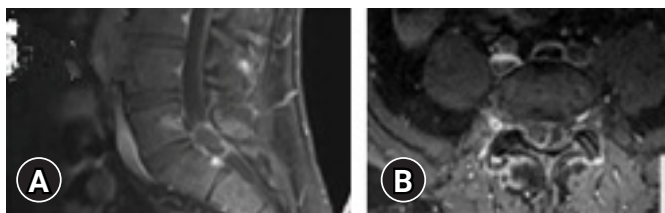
(A) Preoperative sagittal T1-weighted magnetic resonance imaging (MRI) with gadolinium enhancement displaying the L5-S1 intradural neoplasm. (B) Preoperative axial T1-weighted MRI with gadolinium enhancement displaying the L5-S1 intradural neoplasm.
